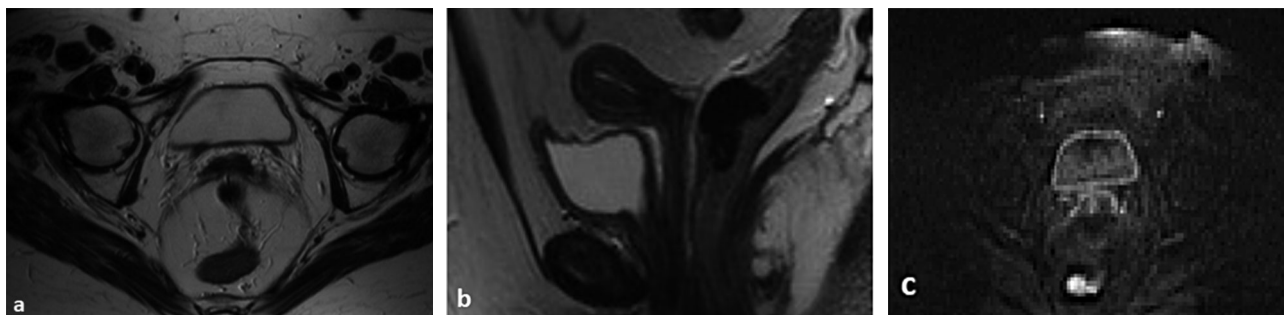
Same patient in Figure 1 with complete regression of pathology after chemo-radiant treatment. MRI T2-weighted images, sagittal view (a). MRI T2-weighted images, axial view (b). MRI DW images and ADC map reconstructions (c-d).
